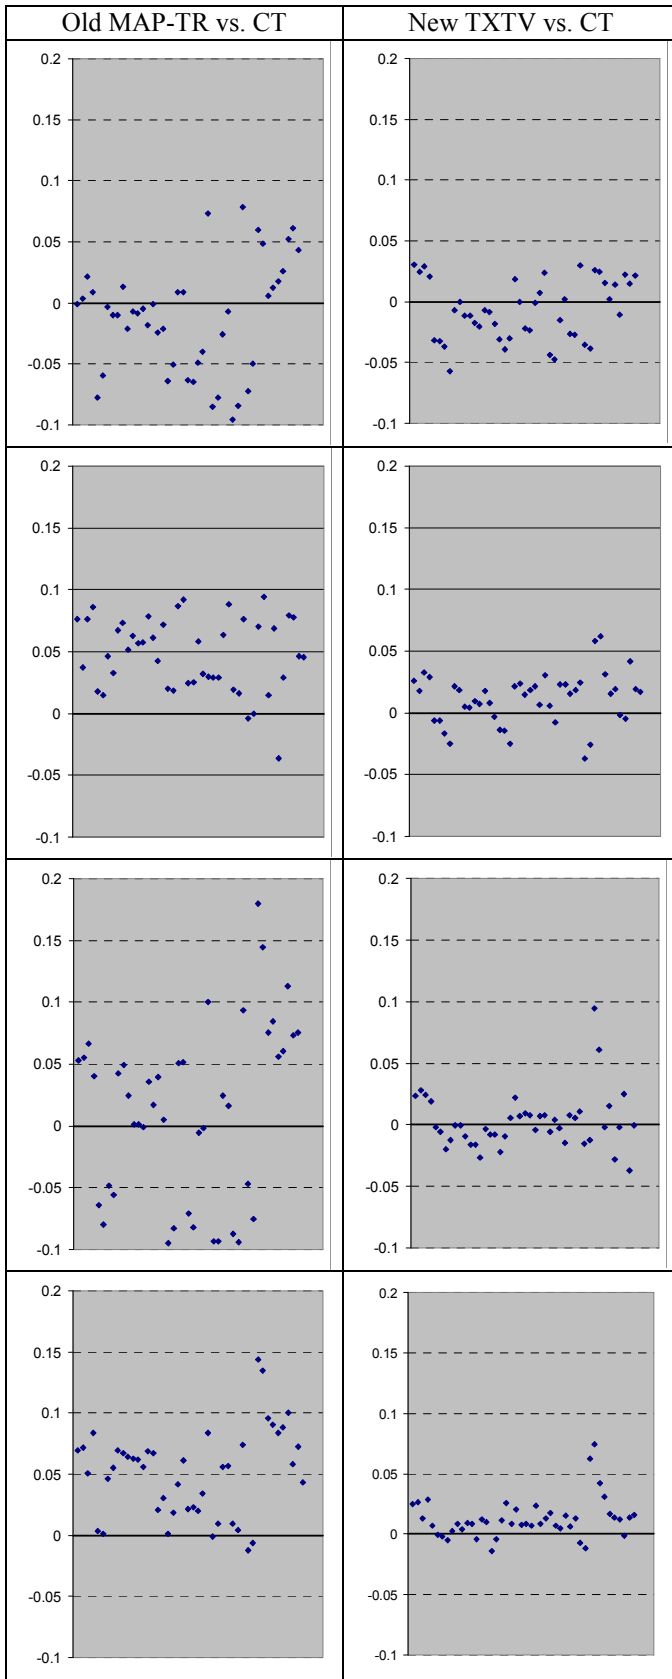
Validation against “gold standard” CT  $\mu$ -maps on emission images by mean values in the 50 Rols. Left column: Old MAP-TR vs. CT. Right column: New TXTV vs. CT. Each row represents a subject. It is clear that the TXTV values in the in the right column are closer to the CT values than the MAP-TR values in the left column
